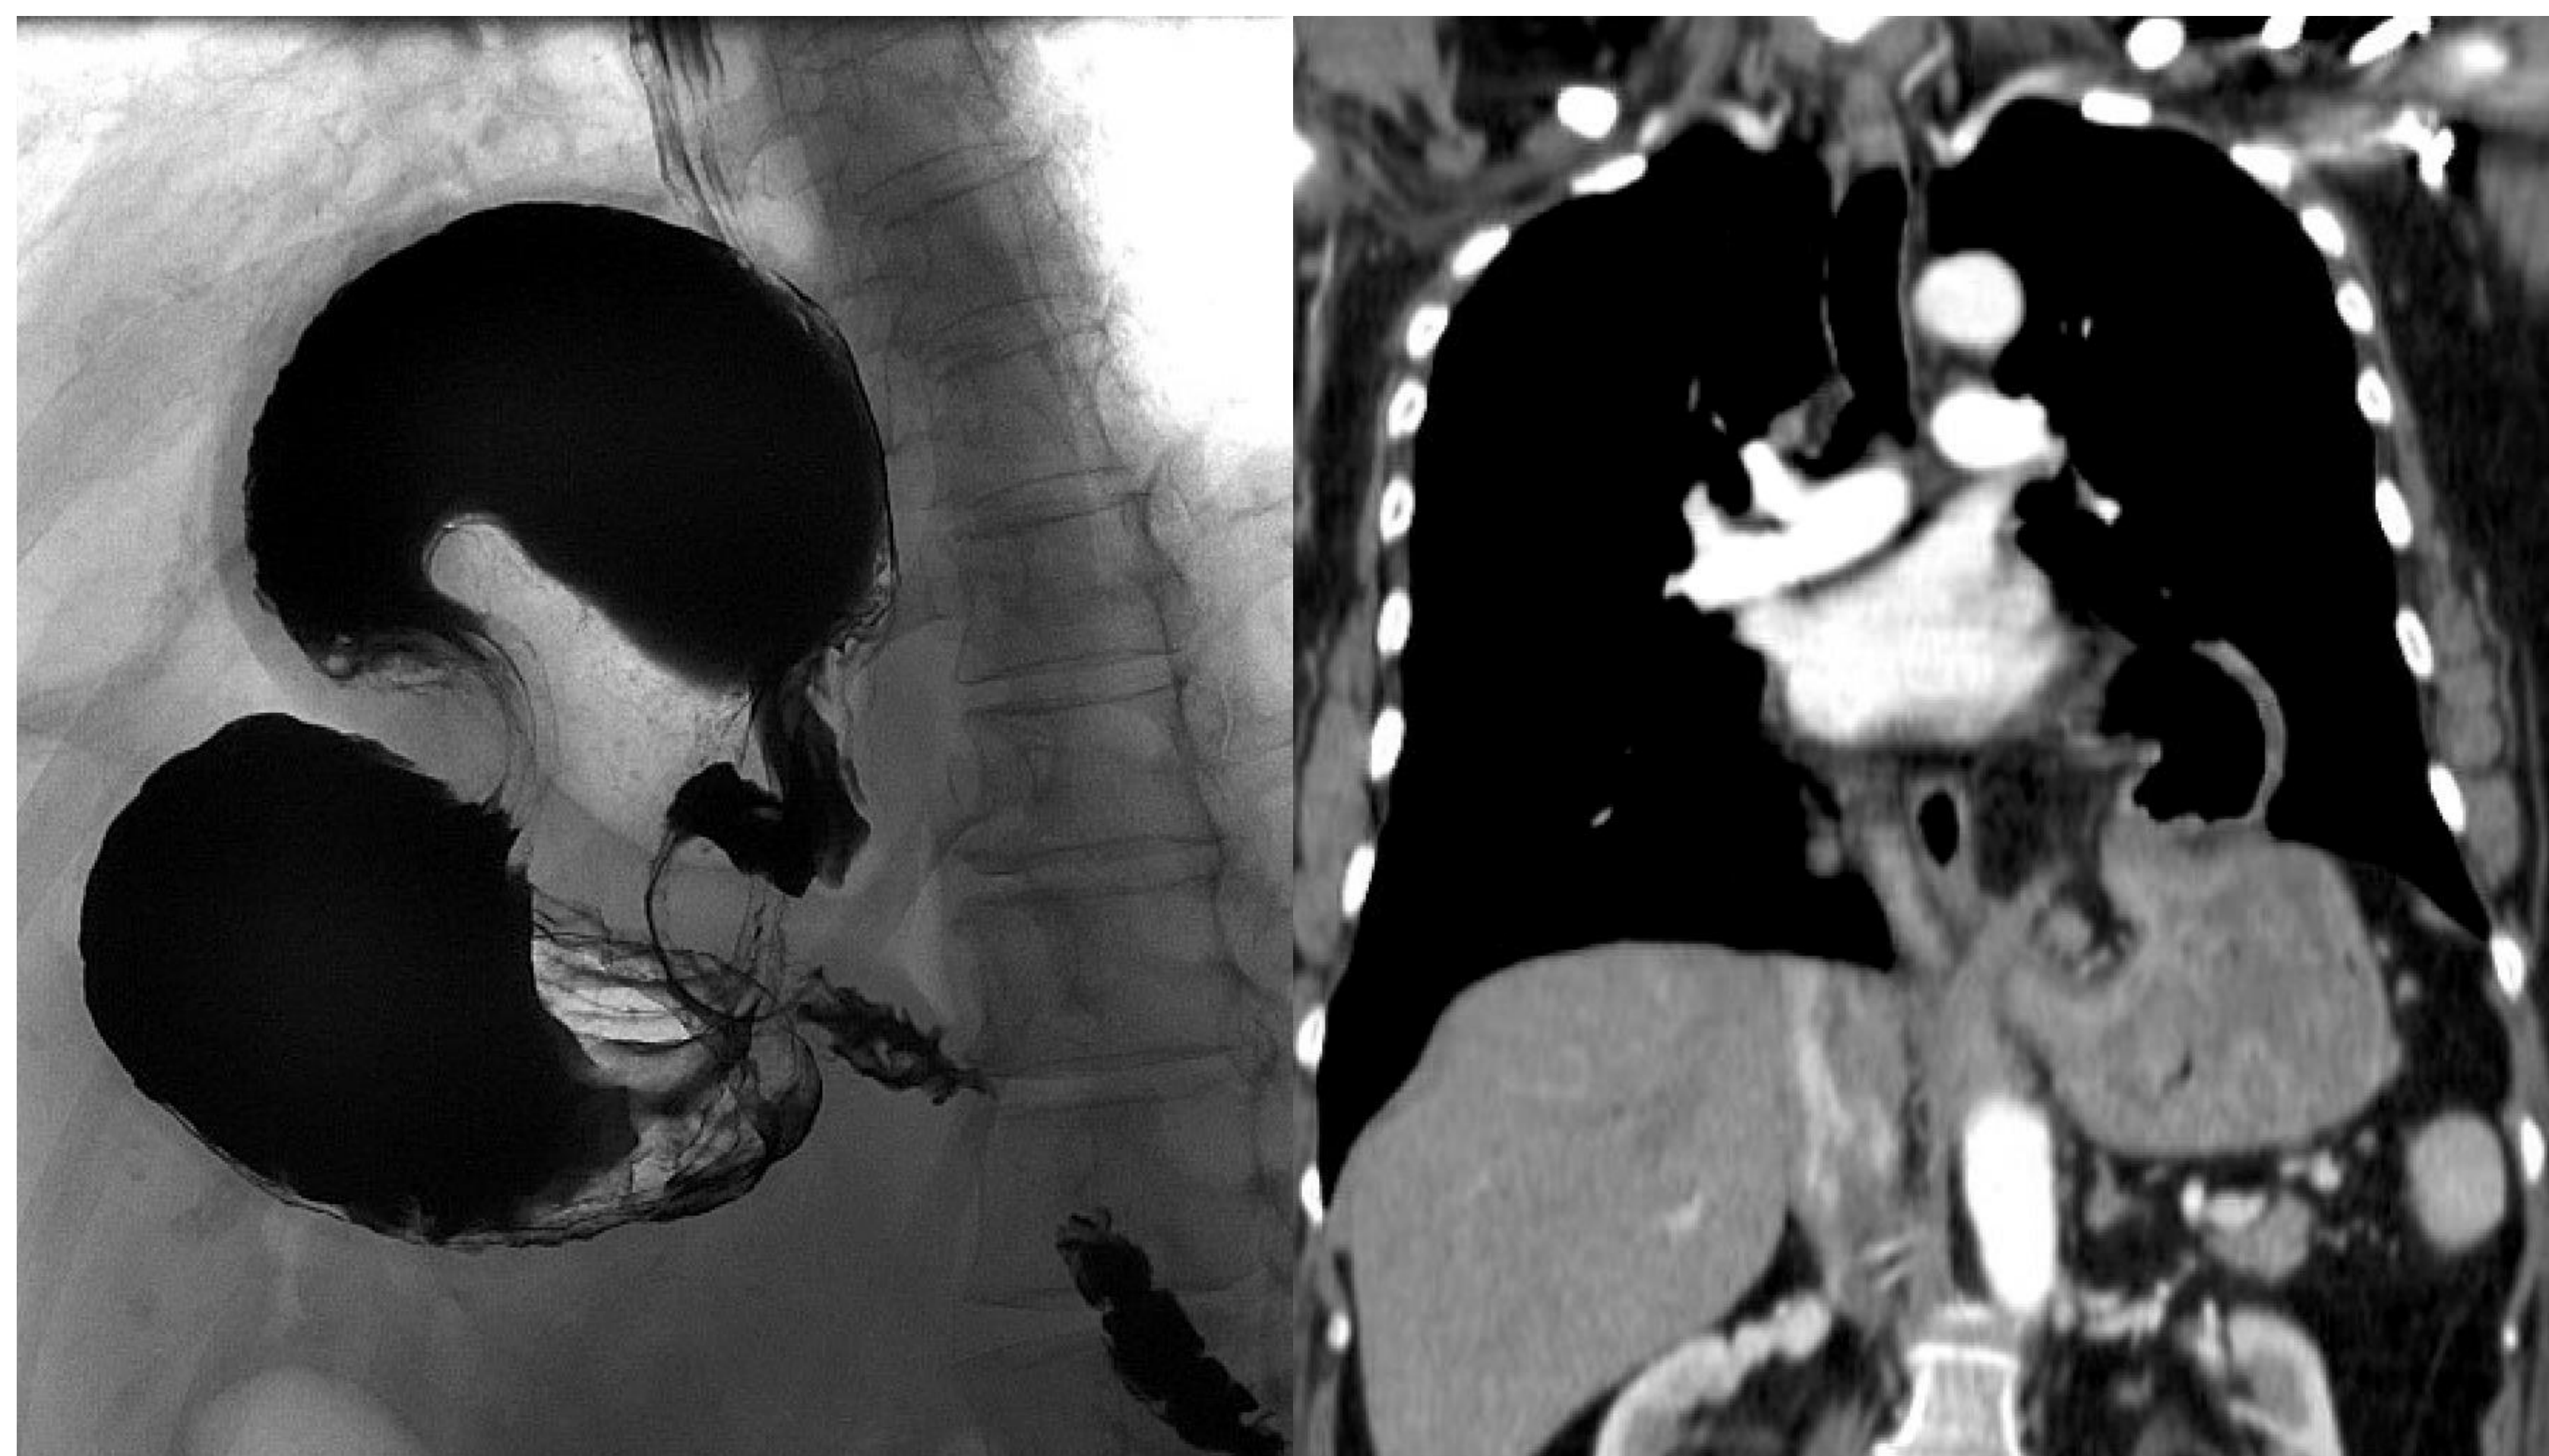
Preoperative Upper GI Study and CT Scan
